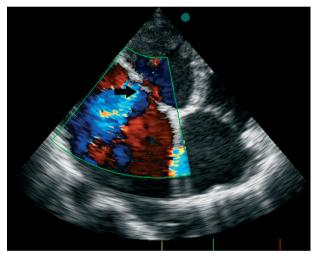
Transthoracic echocardiogram showing a free jet of mitral regurgitation in the apical four-chamber view.
